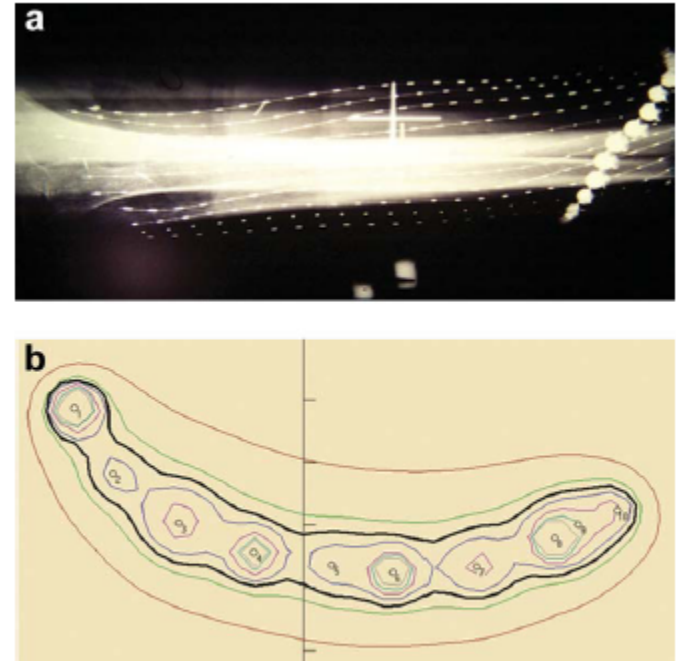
Brachytherapy. (a) Plain X-ray film demonstrating afterloading catheters. (b) Axial dose rate distribution. Solid line represents prescription isodose rate line.
